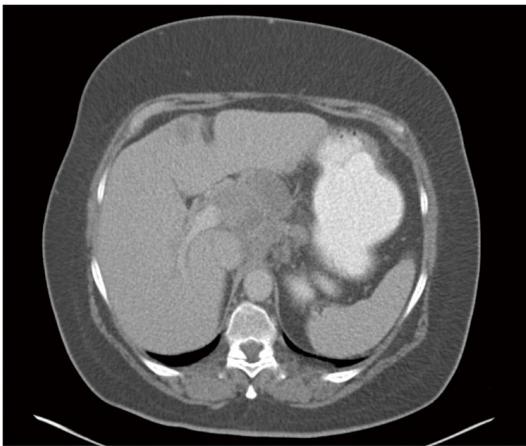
Bulk of adenopathy seen in radiation planning CT
